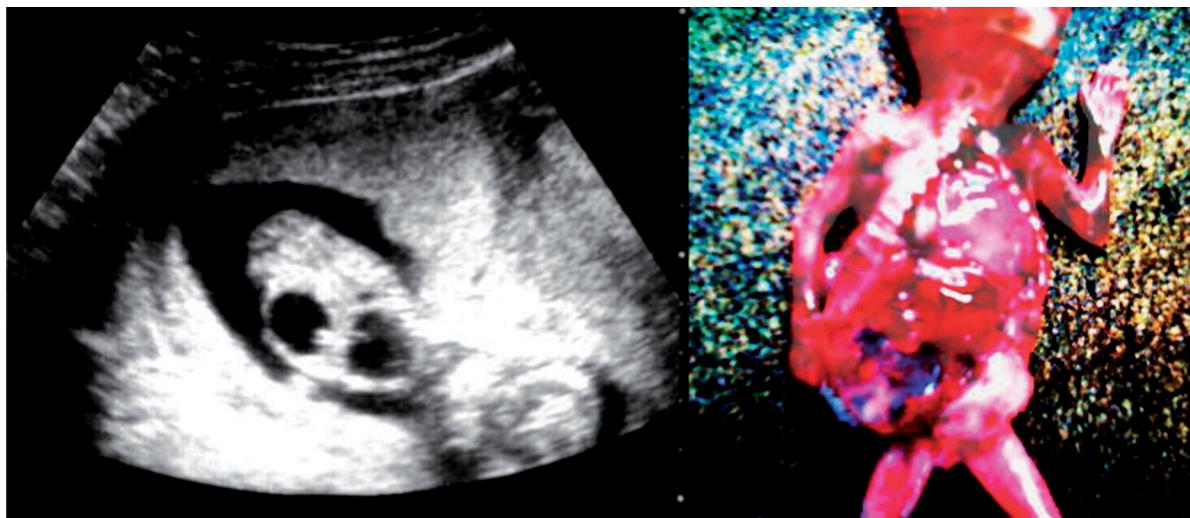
Thoracic enteric cysts located in the fetal left pleural cavity and right hemi-abdomen: sonographic scan at 14 weeks' gestation and macroscopic appearance after termination of the pregnancy.
